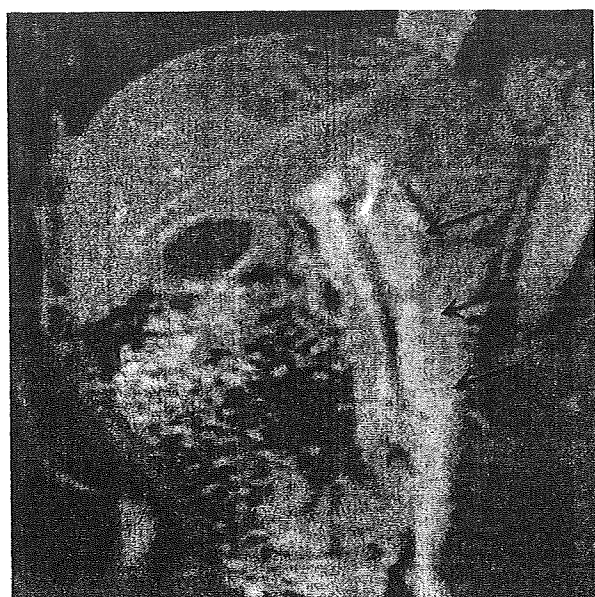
Bile duct lesions in a 50-year-old woman. Coronal contrast-enhanced MRI shows prominent wall thickening of the bile duct with significant laminar structure (arrows).
